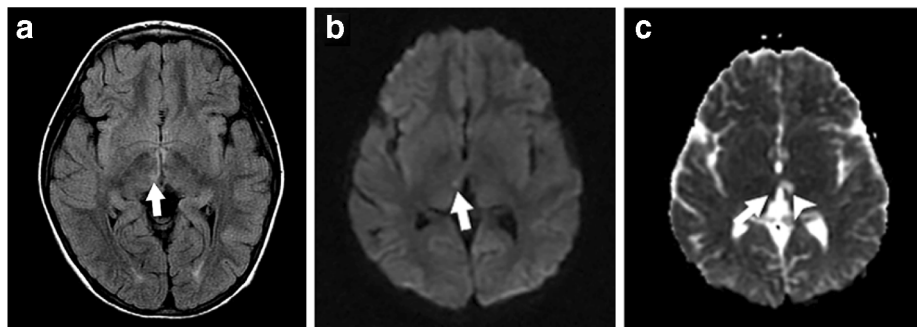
Deficiency of adenosine deaminase 2 in a 5-year-old boy with an 1-week history of diplopia and unsteady gait. a Axial fluid-attenuated inversion recovery MRI of the brain shows a hyperintense focus in the right medial thalamus (*arrow*). b, c Axial diffusion-weighted (b) and axial apparent diffusion coefficient map (c) of the brain show diffusion
